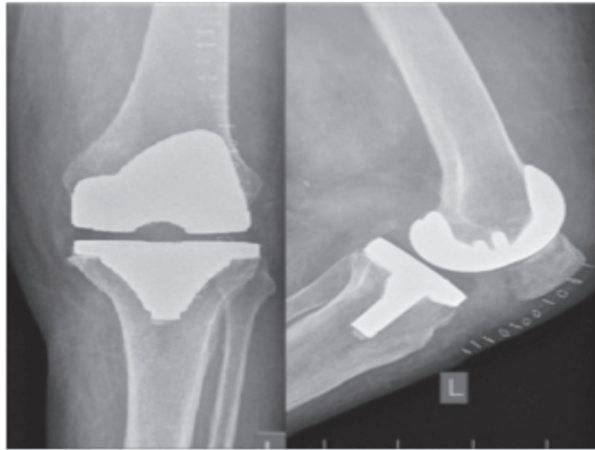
A Radiograph of TKA Using Implant Scorpio NRG
